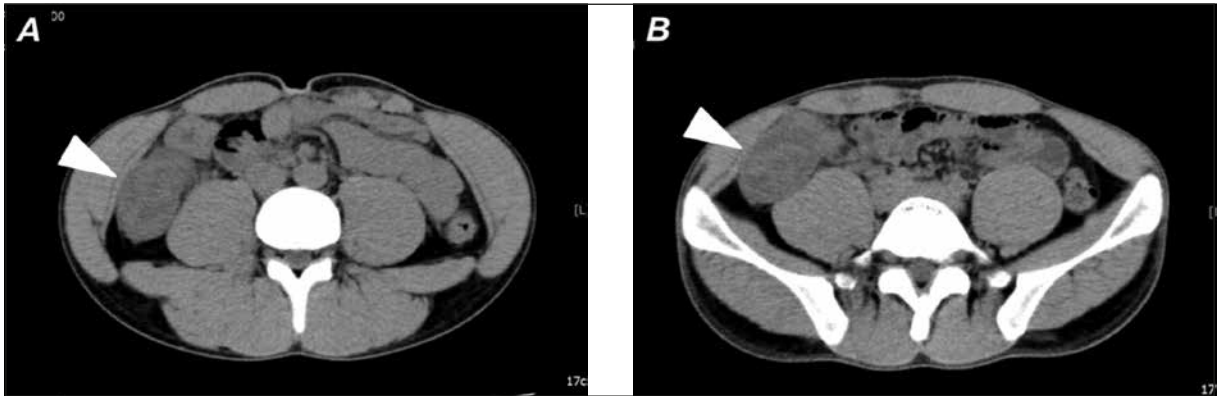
Plain abdominal computed tomography (CT) scanning at the umbilical (A) and pelvic (B) levels. It demonstrated a severely swollen ascending colon with prominent thickening of the bowel walls (arrow heads), showing the appearance of a pseudoabscess-like formation with stratified structures inside. The lesion extended continuously in the right lower abdominal area (A to B). There was no diverticulum in the colon and the appendix was normal.
